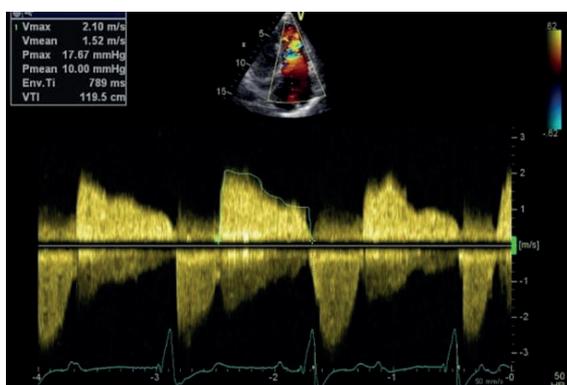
Doppler Echocardiogram showing gradient across the tricuspid valve.
